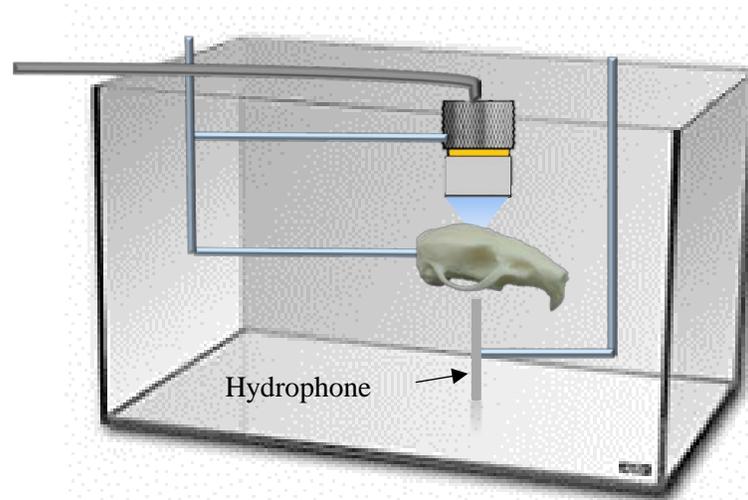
Ex vivo skull scanning system. tFUS is applied to the *ex vivo* skull, submerged in a water tank. A needle hydrophone on a 3D motor is used to scan the ultrasound intensities distributed through the skull.
